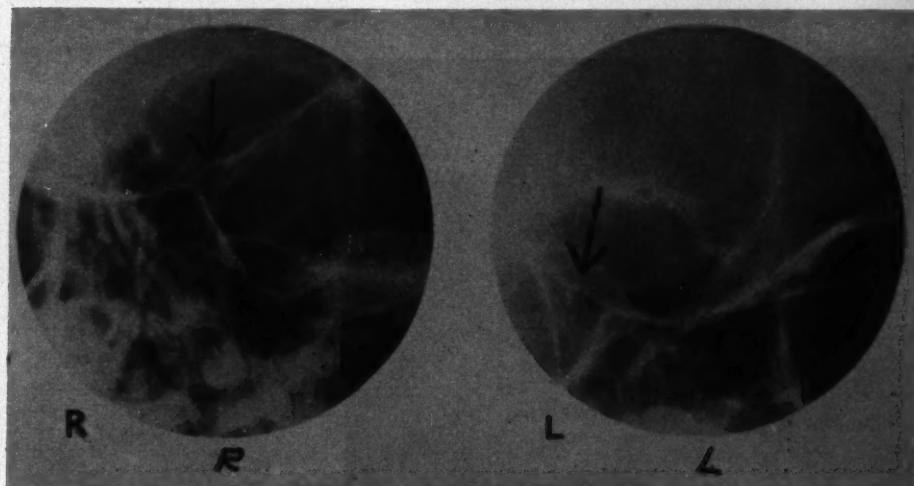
(Carbajal). X-ray films showing moderate enlargement of the left optic foramen. Case 3. (See Figure 14-c.)
